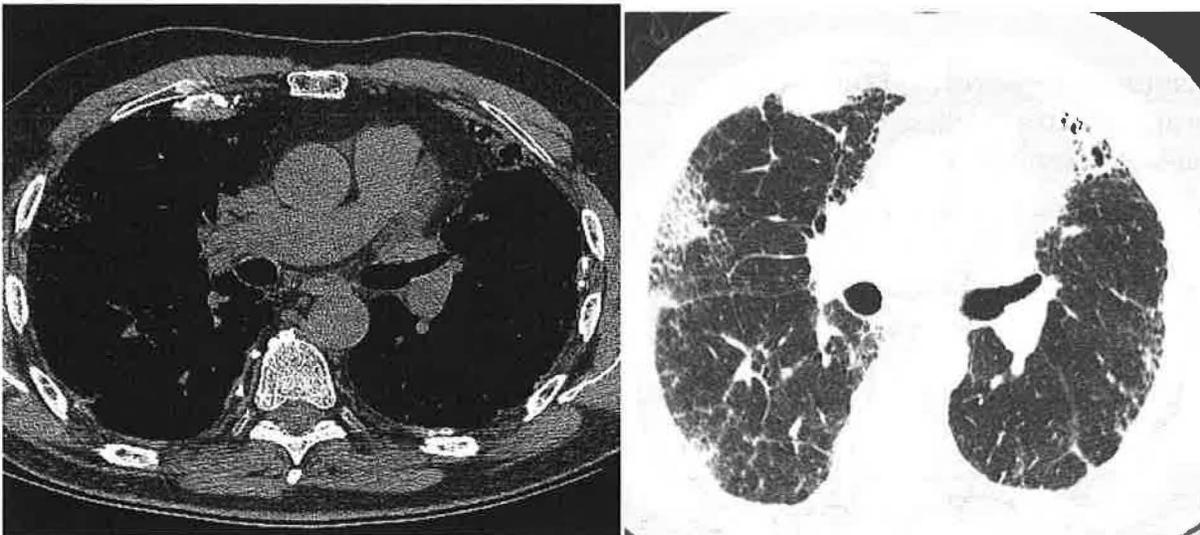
HRCT mediastinal window from the same patient demonstrating the calcified pleural plaques. C) HRCT lung window at the same level demonstrating subpleural intralobular septal thickening and honeycombing from asbestosis.
